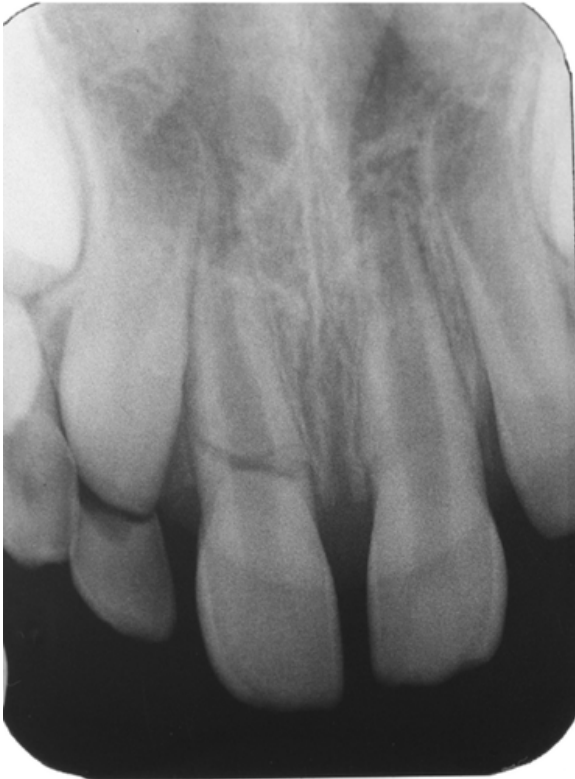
Baseline Radiograph Showing Horizontal Root Fracture on #11
